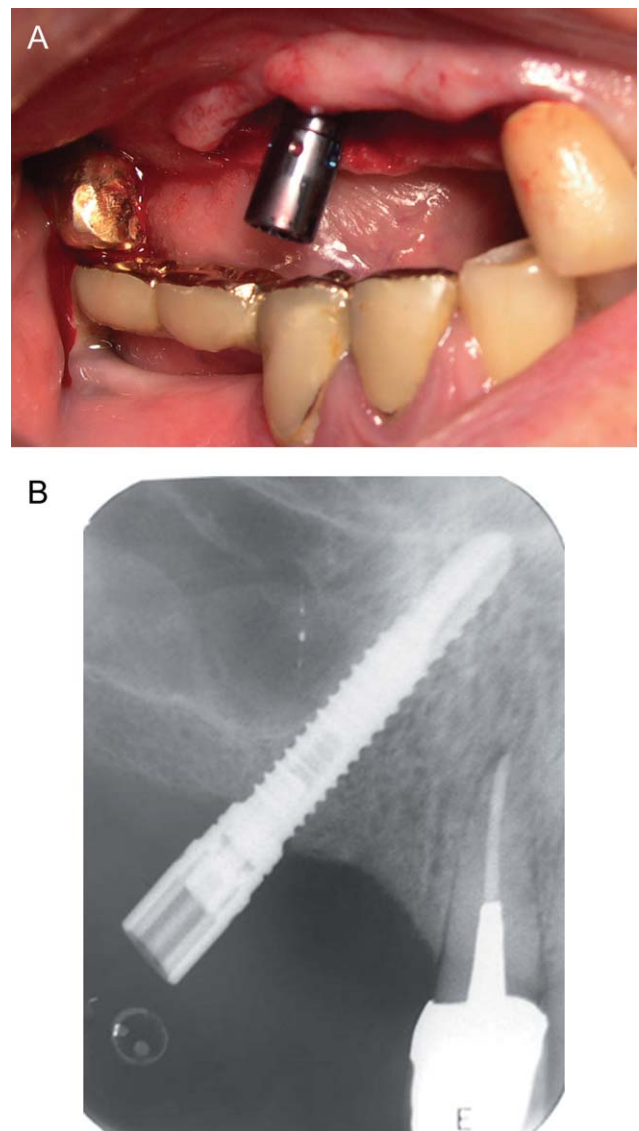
A, Clinical view of the distal implant, immediately after placement. B, Radiographic verification of the distal implant position and its relationship with the surrounding anatomic landmarks, especially the anterior wall of the sinus.
